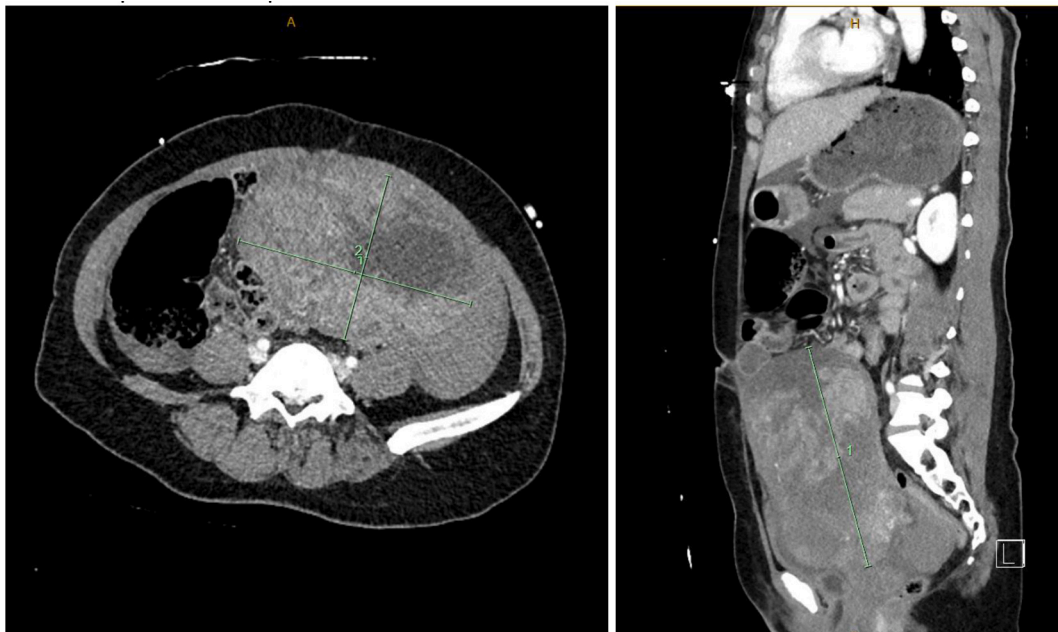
CT imaging showing transverse and sagittal views of the uterus with large leiomyomas and hemoperitoneum present.
